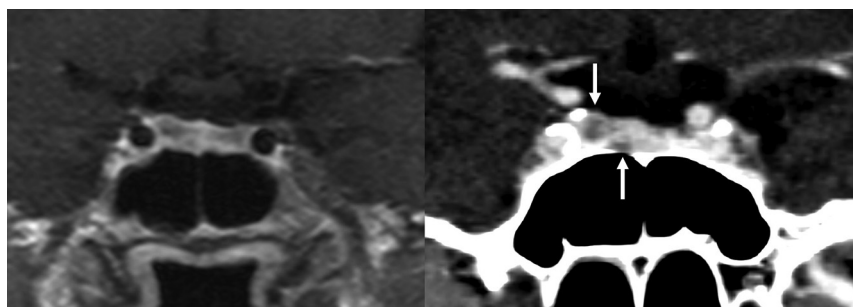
Patient 1, a 67-year-old woman with Cushing disease. Her preoperative dynamic postcontrast T1-weighted image (*left*) shows heterogeneous enhancement in the right pituitary gland without a definite lesion. Dynamic contrast-enhanced PCD-CT (*right*) depicting the third imaging series of the sella with 0.6-mm section thickness shows 2 distinct hypoenhancing lesions (*arrows*) in the right pituitary gland, found to be pathology-proved adenomas.
